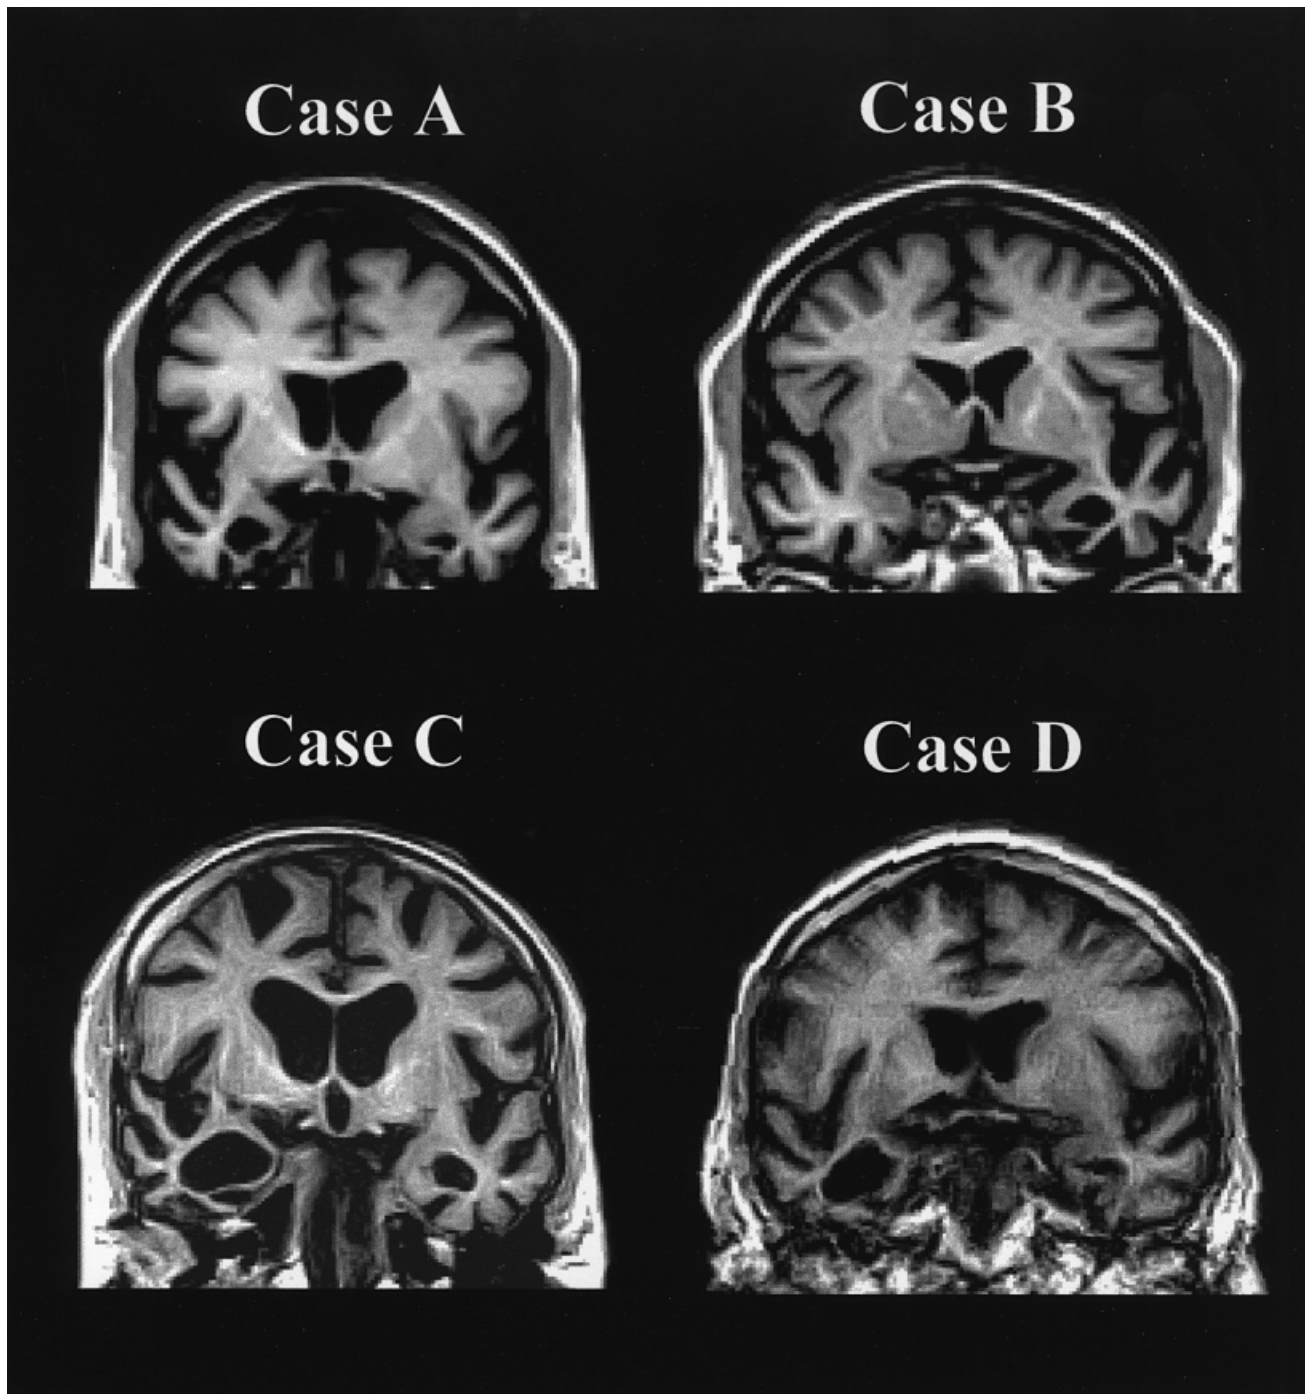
MRI scans showing coronal views through the anterior temporal lobe at the level of the amygdala.
